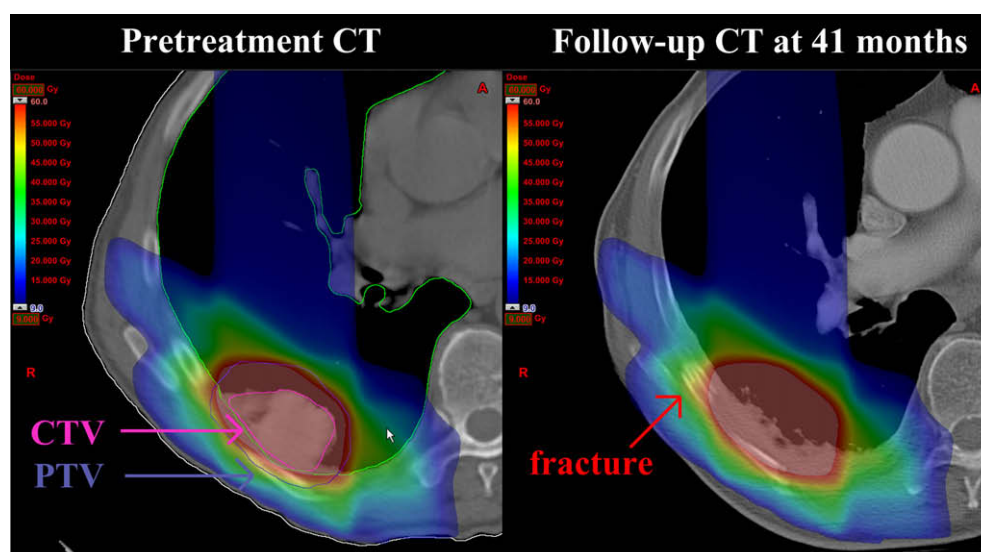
Left: typical dose distribution in the transversal plane (patient number 16 from Table 1). Right: dose distribution in the corresponding plane on the follow-up CT after image registration.
